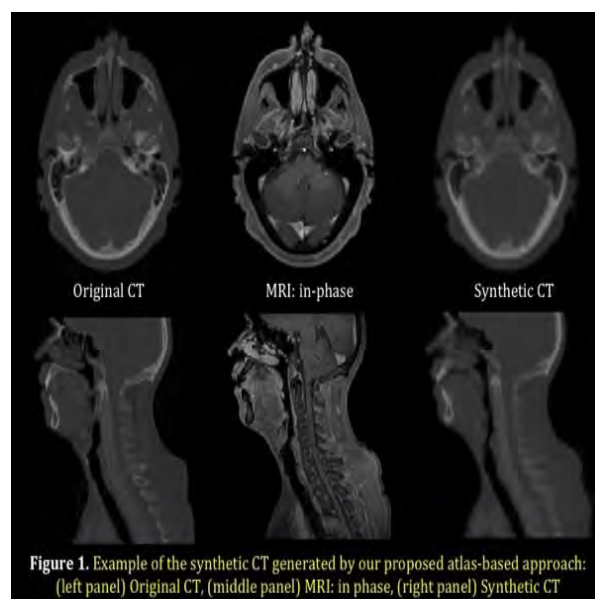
Example of the synthetic CT generated by our proposed atlas-based approach: (left panel) Original CT, (middle panel) MRI: in phase, (right panel) Synthetic CT
